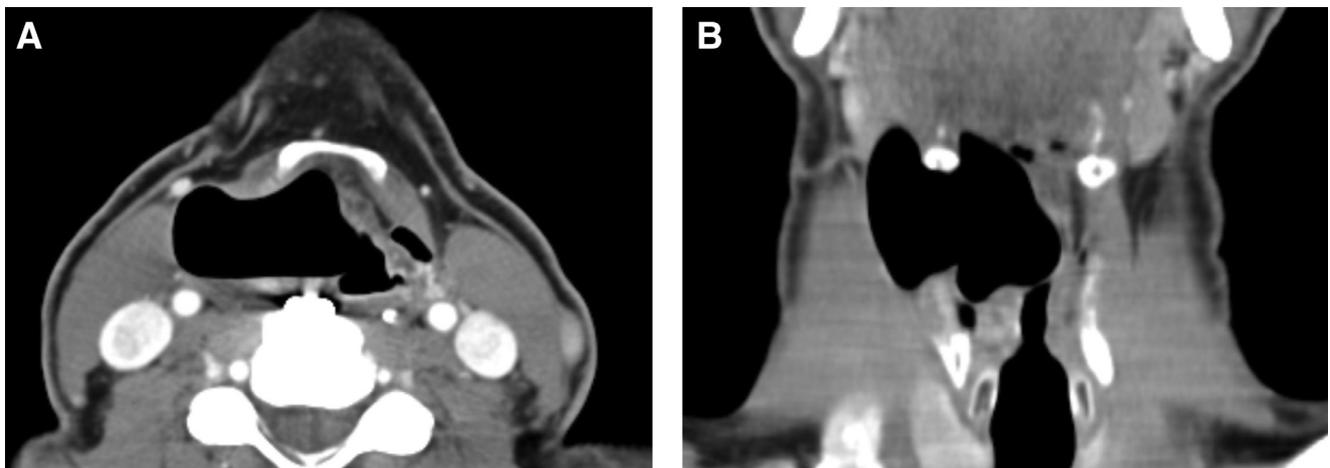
(A) Right combined laryngocele in a 52-year-old male patient. Contrast enhanced axial CT scan at the level of the hyoid bone demonstrates a large air filled structure extending from the endolarynx across the hyoid bone into the neck. (B) Coronal reconstruction further demonstrates the expansion of the laryngocele through the thyrohyoid membrane.
